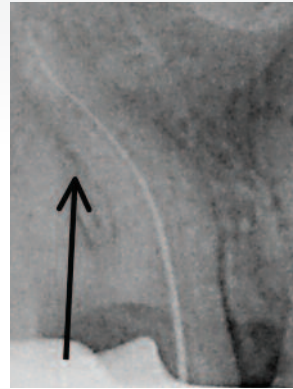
Confirmation of the S-curved root canal configuration in the mesio-buccal root during the length confirmation radiograph with a size 10 K-file
